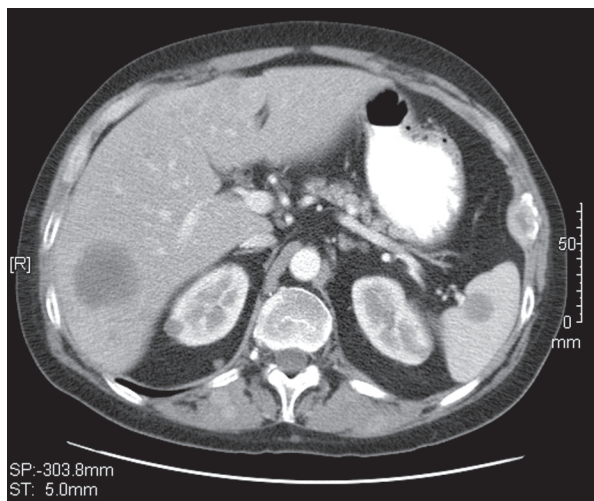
CT scan of the abdomen, with large liver and spleen lesions, before combination chemotherapy with gemcitabine and irinotecan.
